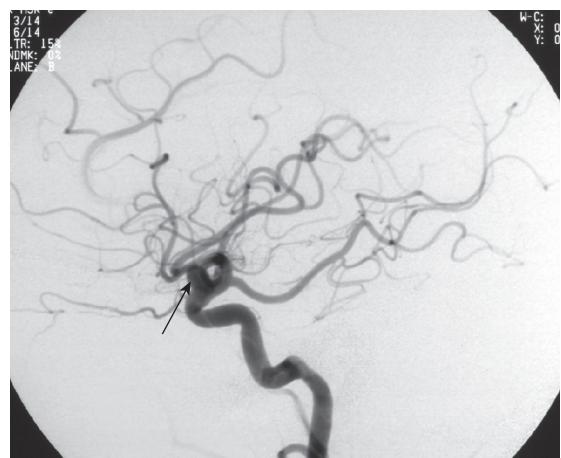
(see right) Incongruous ipsilateral nasal hemianopia (top panel) caused by a lesion on the left side of the optic chiasma (middle panel). An example of such a lesion is an aneurysm of the terminal portion of the internal carotid artery (bottom panel). The radiographic image shows the digitally subtracted arterial phase of a carotid arteriogram of a 48-year-old patient suffering incongruous ipsilateral nasal hemianopia due to such an aneurysm (arrow). (Radiographic image courtesy of Prof. T. Chakera, Royal Perth Hospital.)
